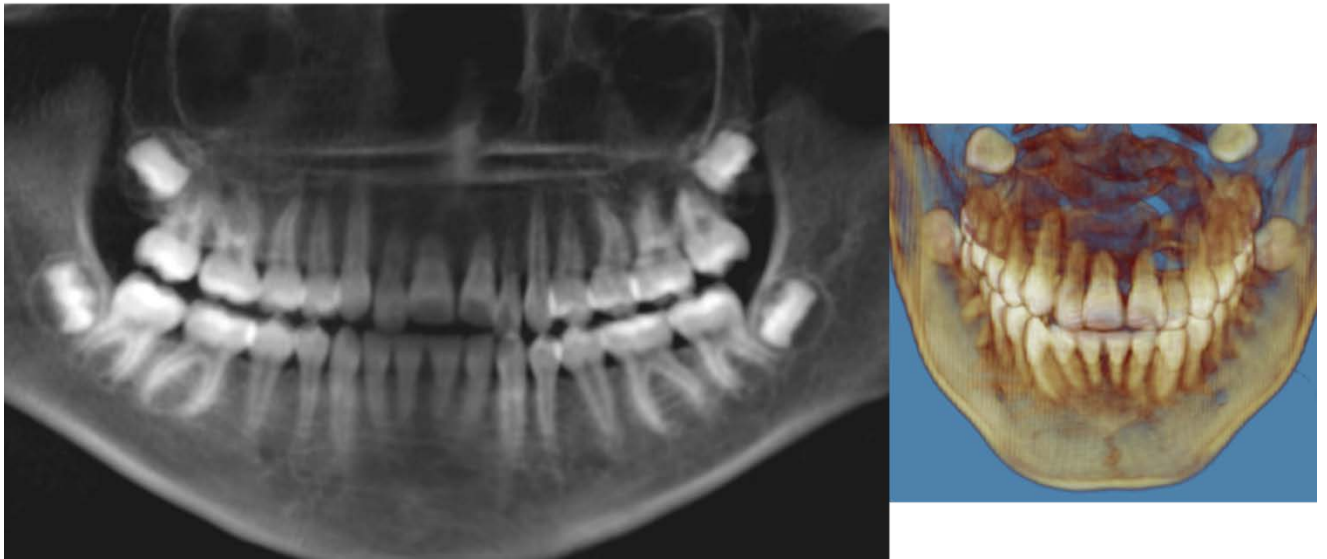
Panoramic radiograph and volume rendering view
